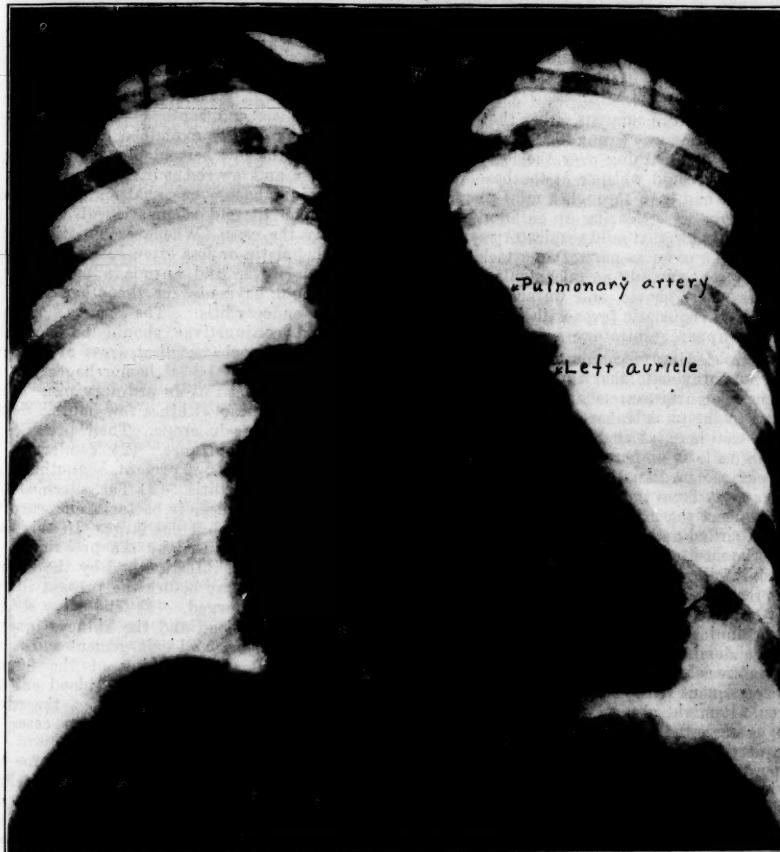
Measurements by X-ray, second entry.
